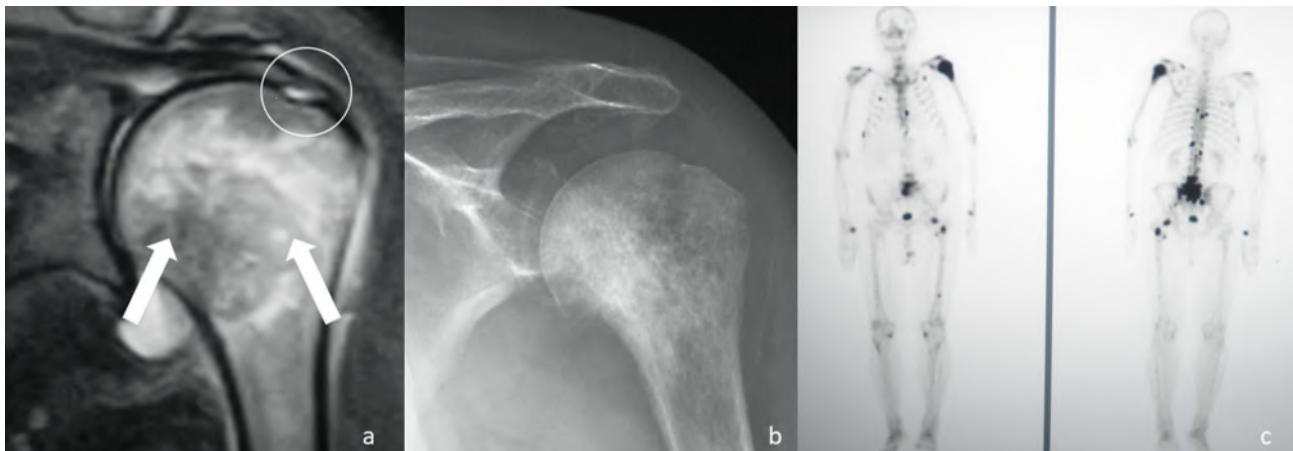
A 67-year-old patient with a history of left shoulder pain for more than one year. He was treated with more than 30 rehabilitation sessions and indicated surgery. (a) Initial image in which the circle marks the rotator cuff lesion. Nobody noticed the alterations of the humeral head. (b) X-rays were requested that had not been requested in the previous consultations in which an alteration in the metaphyseal-epiphyseal region was observed. (c) Scintogram showing pathologically increased uptake in different regions of the skeleton and especially in the proximal end of the humerus. The final diagnosis was a metastasis of prostate carcinoma.
